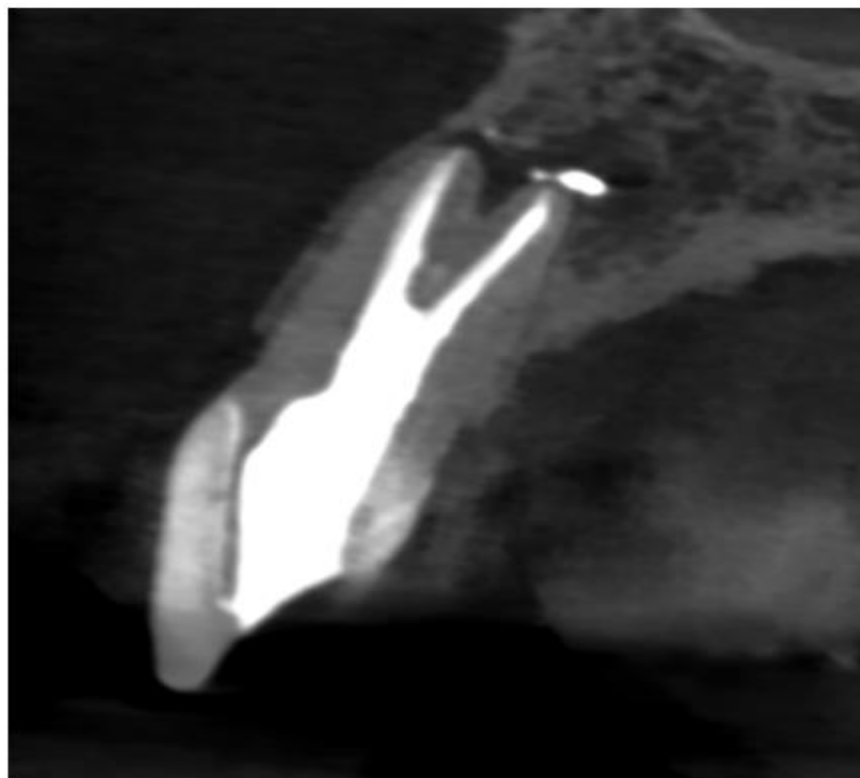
Preoperative CBCT axial view #9.
